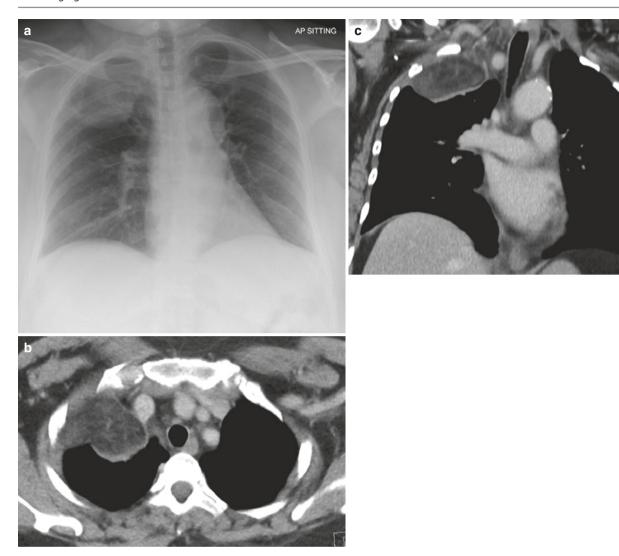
A 49-year-old woman with an incidental pleural lipoma. (a) Frontal chest radiograph shows an extrapulmonary mass (incomplete border sign and an obtuse angle with chest wall) with low density over the right upper zone. (b, c) Axial and coronal CT images show a
